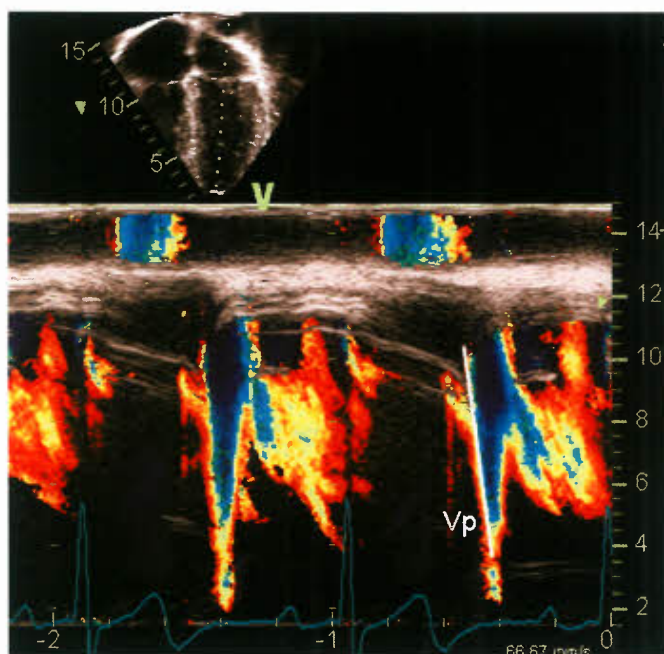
The velocity of flow propagation (V_p) into the left ventricle (LV), an index of LV relaxation, is obtained by color M-mode. An M-mode scan line is placed from the LV apex through the mitral valve with simultaneous color Doppler flow. The color scale (Nyquist limit) is lowered until aliasing is obtained. The slope between the first and second aliasing velocity is measured as the V_p . A more shallow slope indicates impaired relaxation. Normal data for pediatric V_p are not available.
